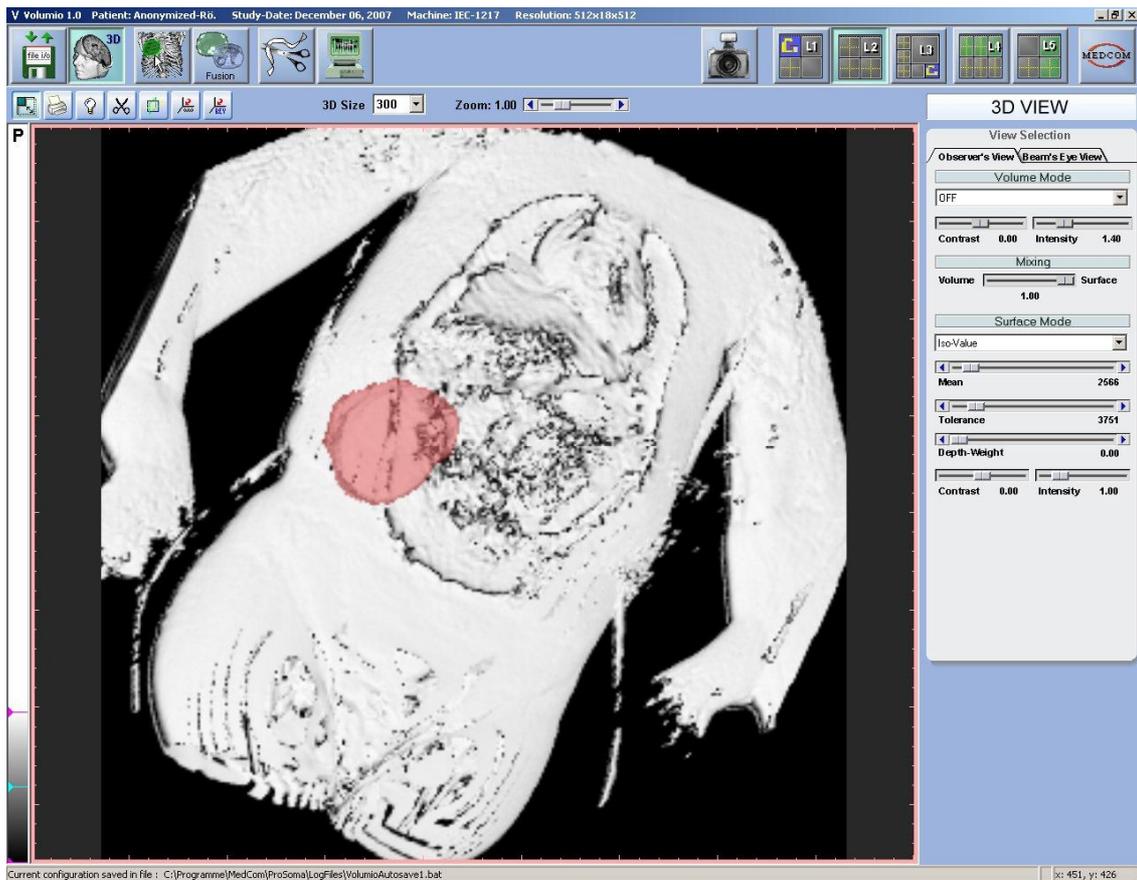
3D Visualization of tumour and thorax in a MR image.
